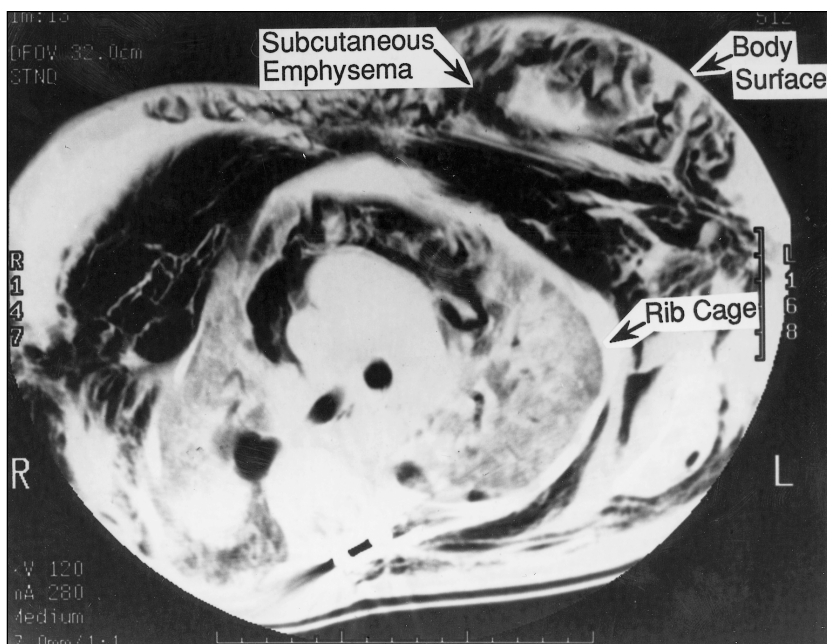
CT scan of the chest showing massive subcutaneous emphysema.
